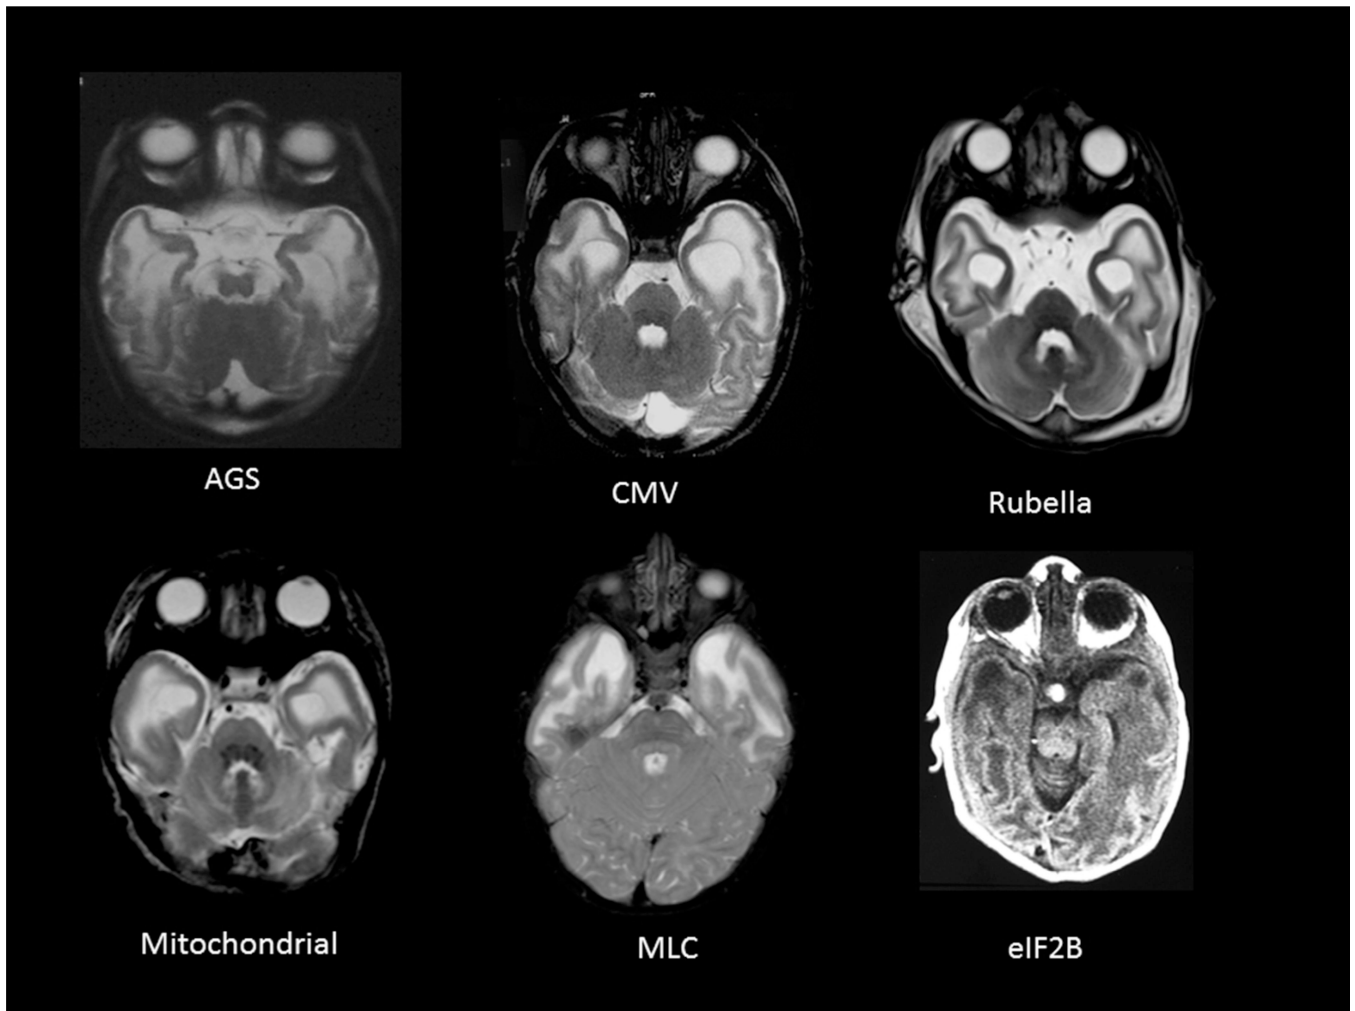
Swollen temporal lobes on MRI
